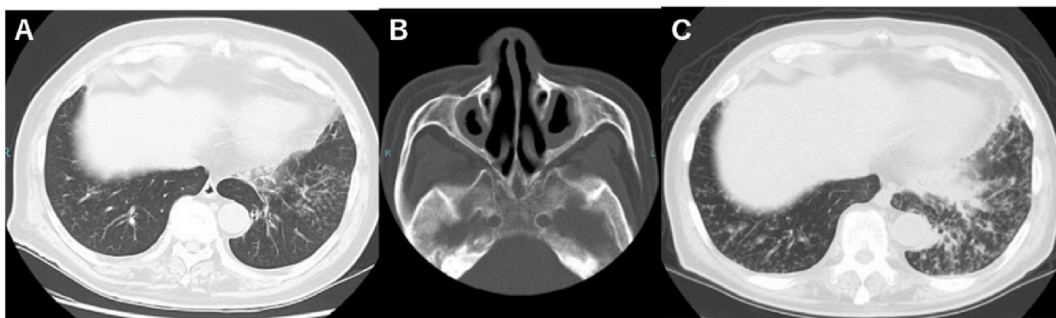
A: August, X-2, chest CT scan showed lobular central granular shadows and bilateral bronchial wall thickening in the lower lobes. B: July, X-1, sinus CT showed soft shadows in both maxillary sinuses and anterior ethmoidal sinuses, raising the suspicion of chronic sinusitis. C: February, X, bilateral granular shadows worsened slightly on CT imaging. CT, computed tomography.
